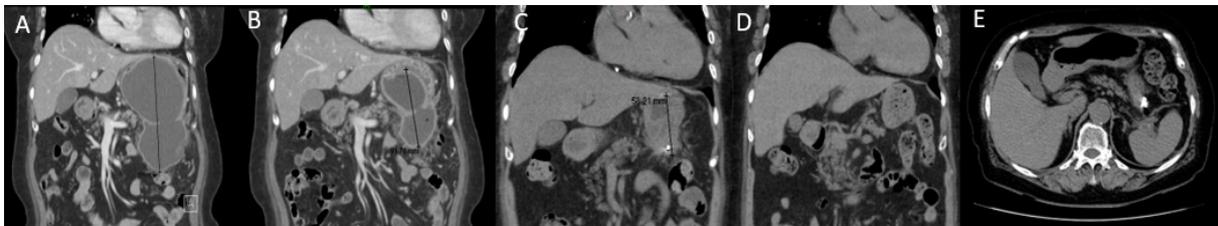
CT scan showing pseudocyst of pancreas A) Large pseudocyst causing extrinsic compression of stomach B) The size of pseudocyst decreased to 9cm C) The size was much decreased to 5.8 cm two weeks later D, E) Pseudocyst was disappeared 3 months after the initial onset
